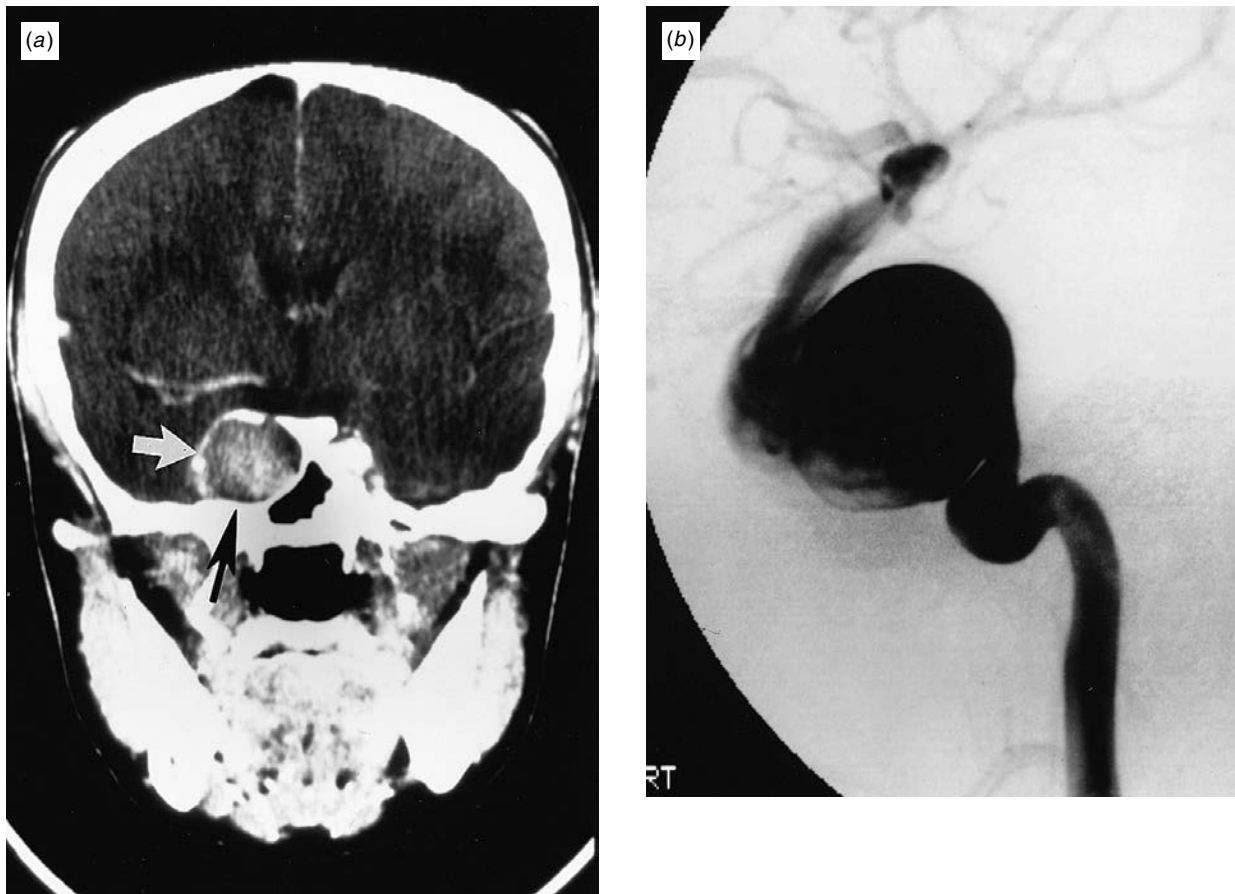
(a) Coronal computed tomography with contrast (from an 18-year-old with headaches and a family history of Ehlers–Danlos type IV) reveals a large aneurysm (arrow) of the intracavernous carotid artery. (b) Internal carotid angiogram confirms the giant aneurysm of the intracavernous carotid artery. (Reproduced from Roach & Zimmerman, 1995, with permission.)
